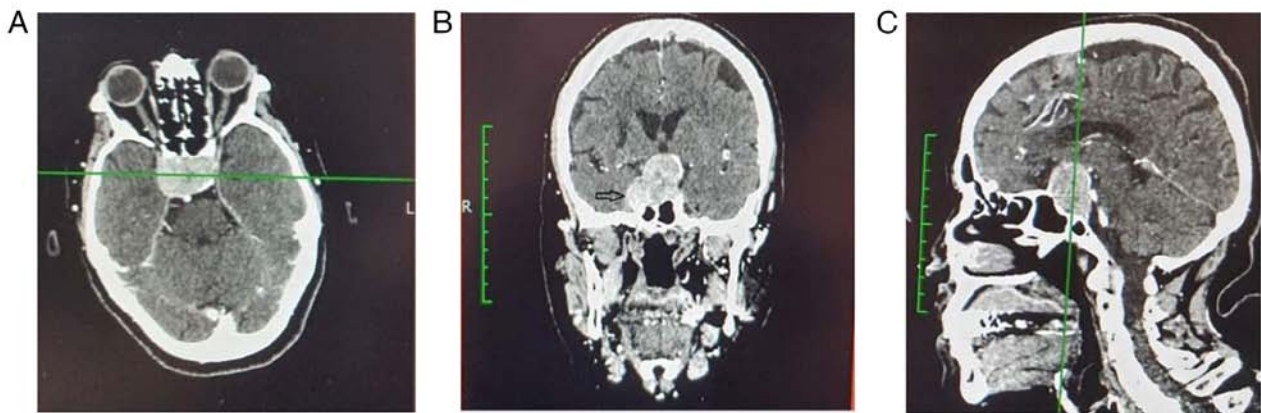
(A-C) Pre-operative contrast enhanced computed tomography scan of patient 1, depicting a large pituitary macroadenoma. Note the extension of the lesion to the right cavernous sinus (arrow).
